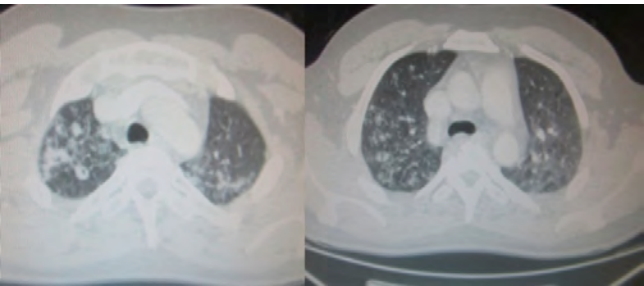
Thorax CT – Tree-in-bud infiltration at the right and left upper lobes of the lung and cavity in the right upper lobe.
